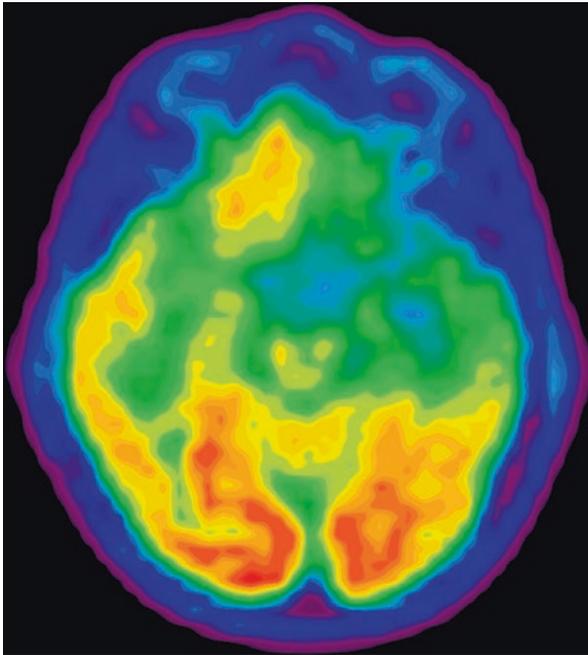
FDG-PET (*axial view*). Note profound hypometabolism of the left anterior temporal lobe
